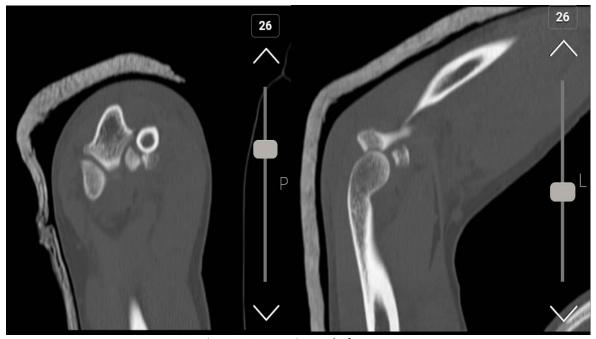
CT scan image before surgery
